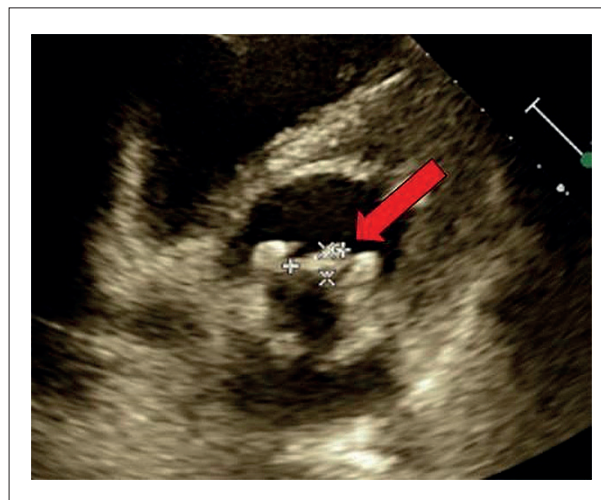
Transesophageal echocardiogram demonstrated a biological prosthesis with thickening of one of the leaflets located topographically close to the aorta, with an image suggestive of vegetation.
